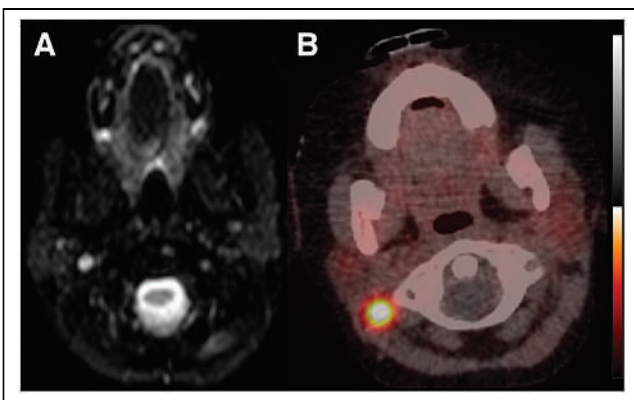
Persistent right-neck lymph node uptake on ^{68}Ga -DOTATATE PET/CT (B) that has normal size and other morphologic criteria on correlative short-tau inversion recovery MRI (A).
